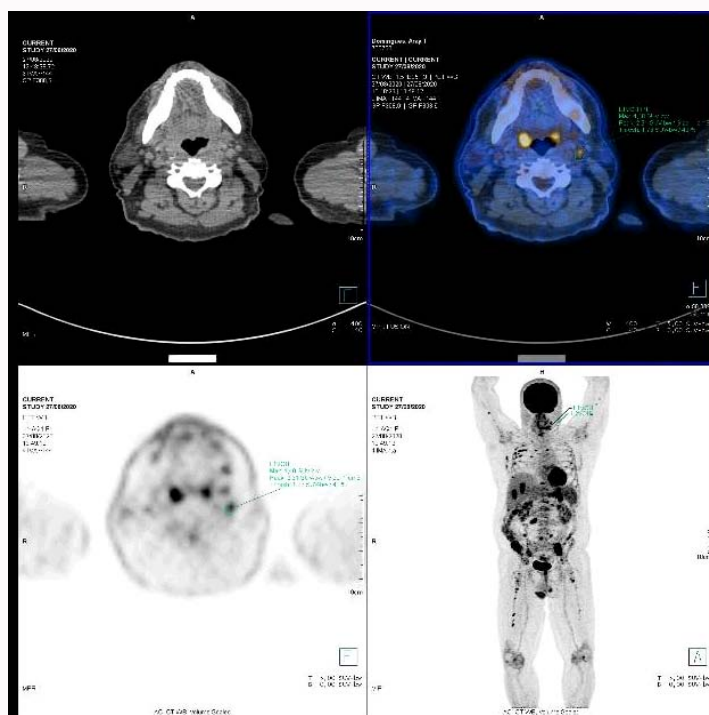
PET-CT which identified glycolytic hypermetabolism in lymph node, splenic, hepatic lesions, large gastric, enteral, testicular, lumbar and medullary root curvature (with signs of nerve and muscle-adipose infiltration), suggestive of impairment neoplastic.
